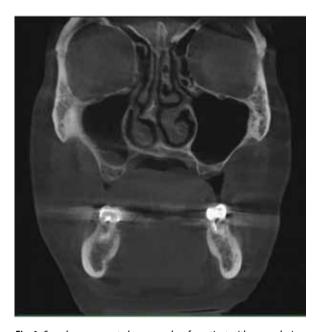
Cone-beam computed tomography of a patient with severe deviation of the nasal septum to the left
